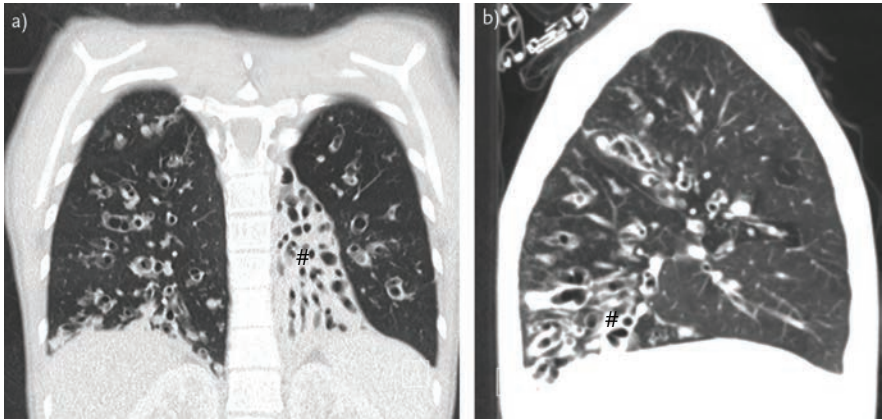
CT scan of a 15-year-old female CF patient (same patient as in fig. 2) a) coronal plane view and b) sagittal plane view of the left lung. Bilateral mucus plugging and bronchiectasis, as well as atelectasis of the left lower lobe (#) is clearly visible. Image courtesy of E. Stranzinger (Division of Radiology, University Children's Hospital of Bern, Bern, Switzerland).
